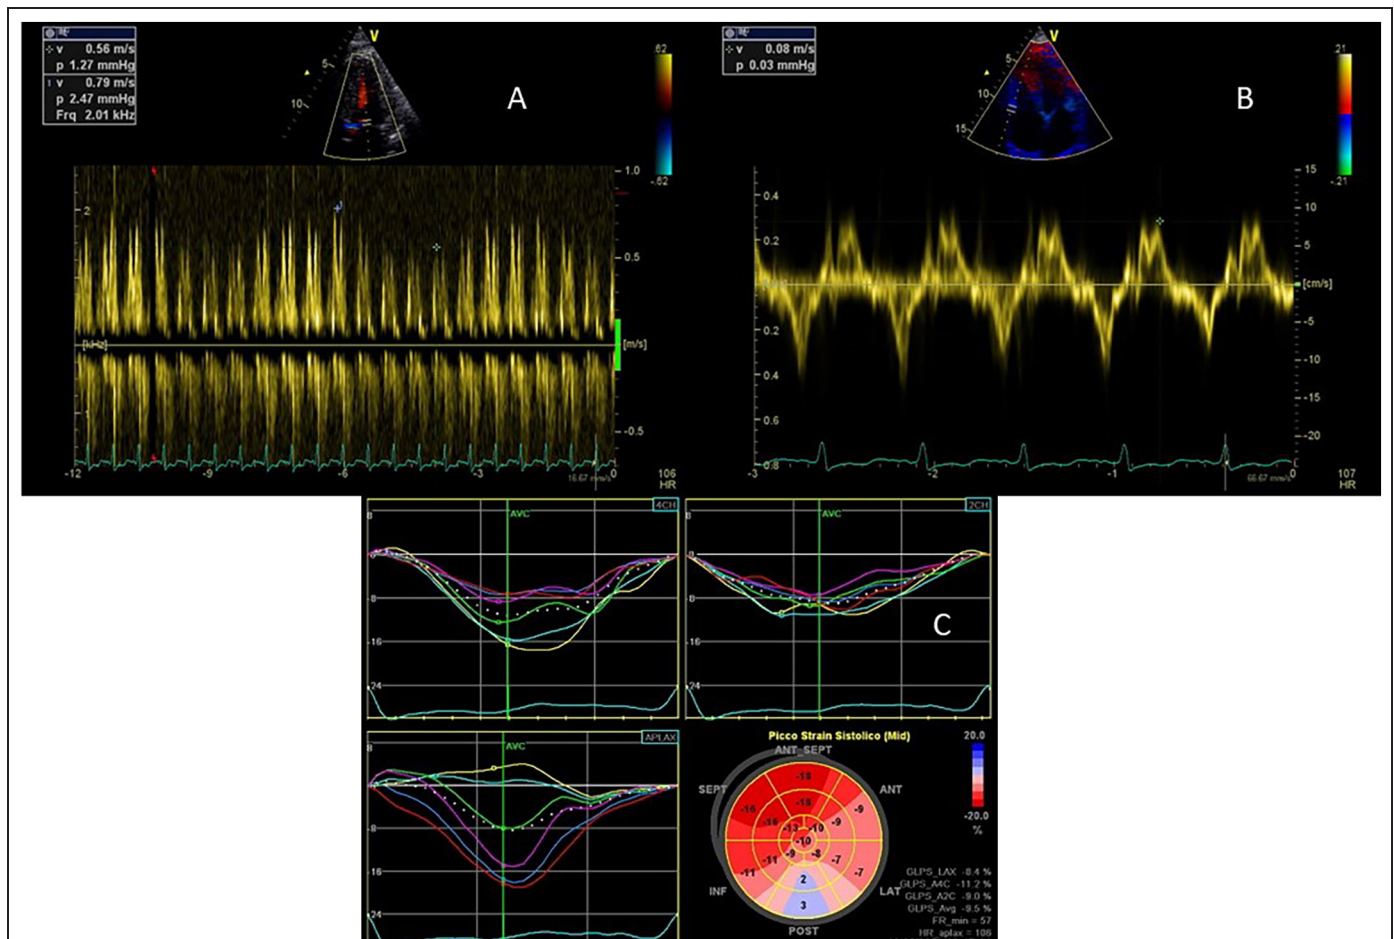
Echocardiography at the time of diagnosis. (A) Respiratory variation of the mitral peak E-wave about 29 % (pulsed wave Doppler sample volume at the level of the mitral leaflets). (B) Reduction of the right ventricular systolic longitudinal function (tricuspid annular velocity S' wave with tissue Doppler imaging, 8 cm/s); (C) Left ventricle global longitudinal strain at the time of diagnosis (−9.5 %). A clear reduction of longitudinal strain is observed in the lateral and posterior regions of the bull’s eye (so called “strain reversus” phenomena).
